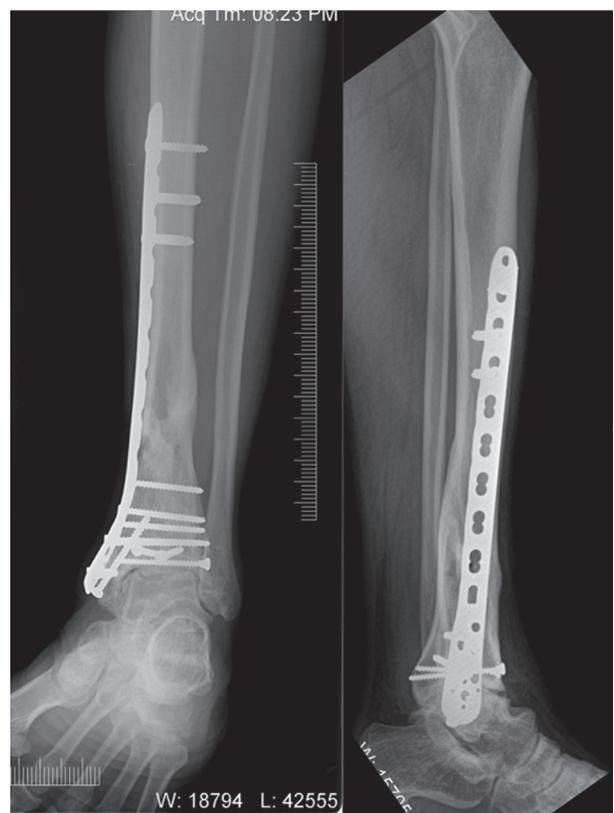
Postoperative X-ray showing fixation of the Pilon addressed by 4-column concept
